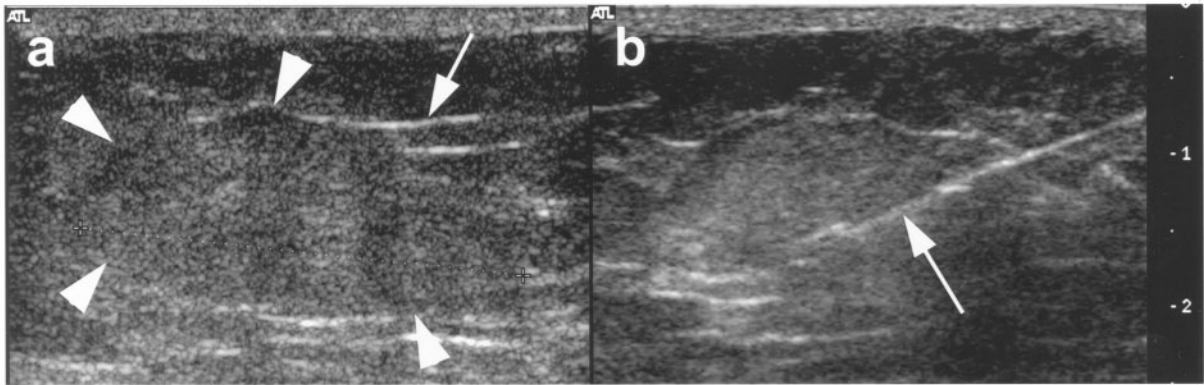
(a) Ultrasound images demonstrate a relatively well-defined lobulated mass (arrowheads) within the superficial fascia. The lesion is slightly hyperechoic to the adjacent subcutaneous fat and has a granular echo texture. Normal interlobular septae (arrow) are absent. (b) The bevel (arrow) of a true cut biopsy needle is demonstrated within the lesion just prior to sampling.
